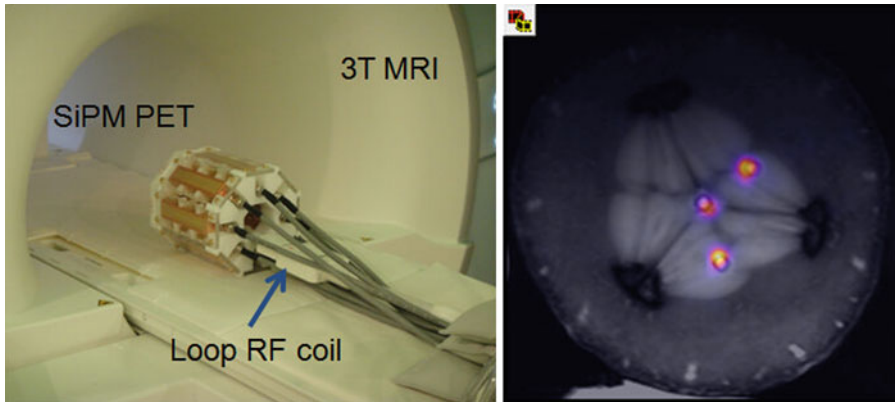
SiPM-based MRI-compatible PET for simultaneous PET/MRI (Reprinted from [46] with permission)
